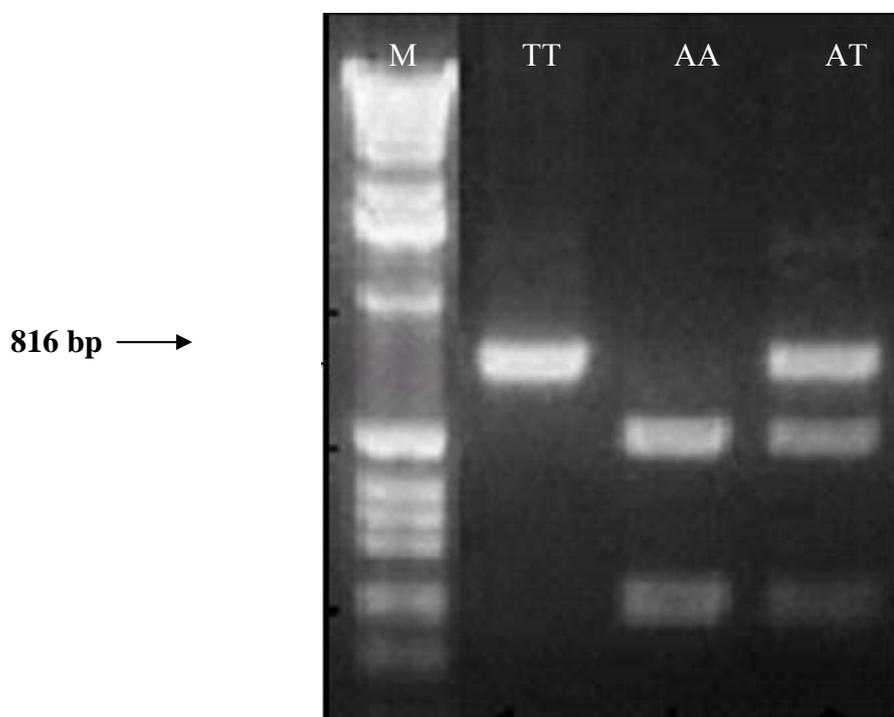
Differentiation of the IL-8-251A/T promoters by *MfeI* digestion; M: ladder, TT: Thymine Thymine, CC: Cytosine Cytosine, CT: Cytosine Thymine
